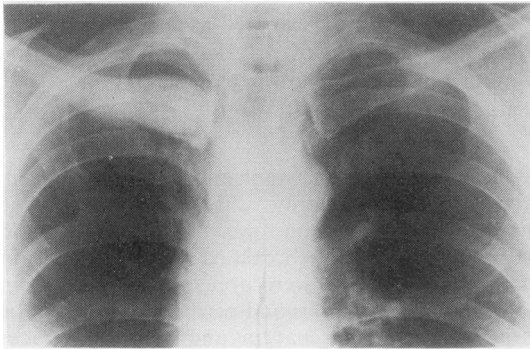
Radiograph of osteoblastic metastasis in the right clavicle.
